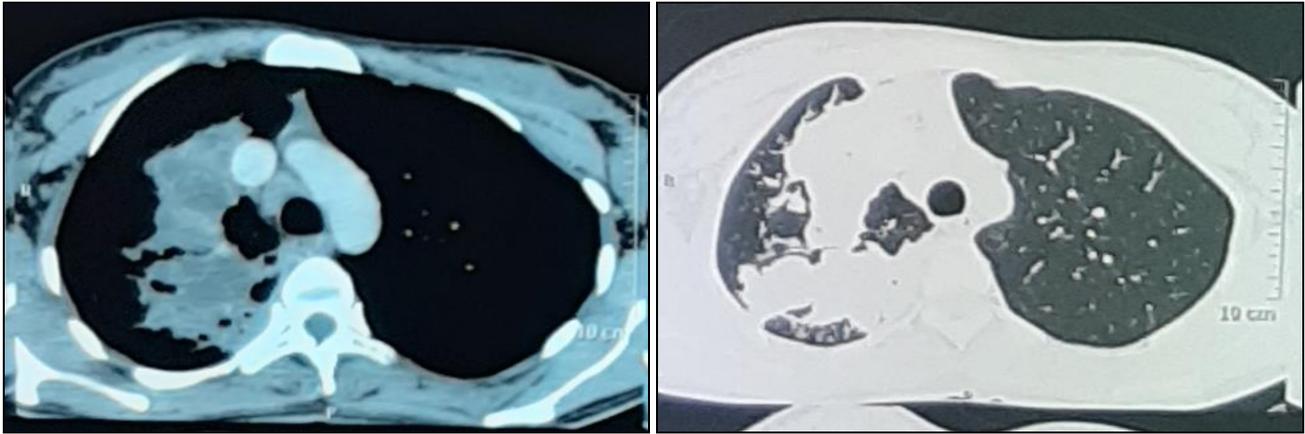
Contrast enhanced CT scan of the thorax (mediastinal window, A) showing a centrally situated mass in the right upper lobe. Focal bronchiectasis is seen adjacent to the mass (lung window, B).
